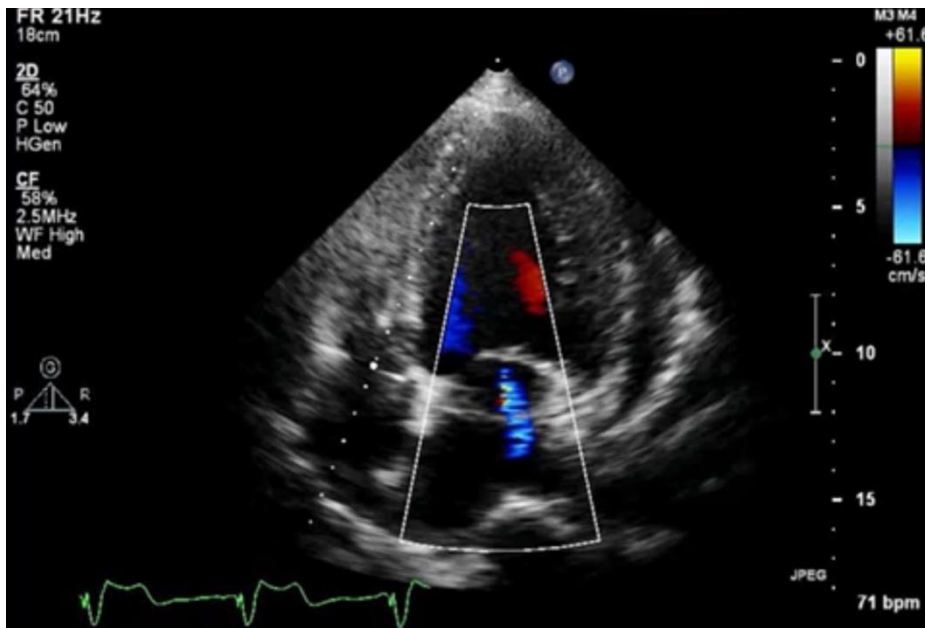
Follow-up monitoring using 4-chamber transthoracic echocardiography in which color Doppler ultrasound shows mild-to-moderate mitral regurgitation
